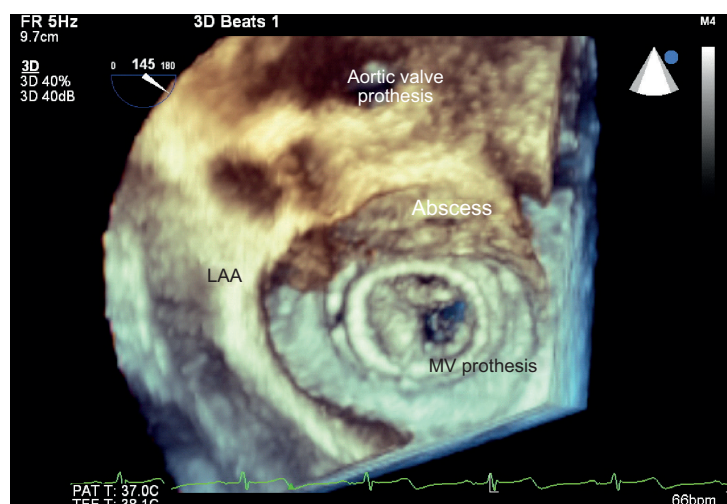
Three-dimensional transesophageal echocardiogram images showing aortic periprosthetic neocavity extending to the mitroaortic junction.
